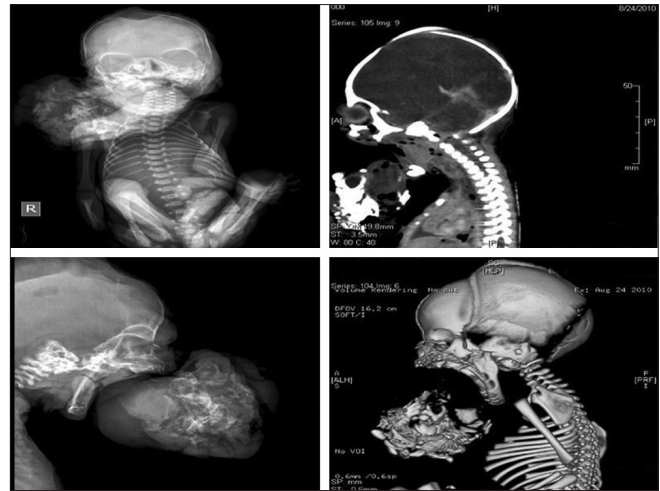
(a) Postmortem plain anteroposterior radiograph of the baby showing heterogeneously dense intraoral mass. (b) Lateral view of the mass. (c) Sagittal reformatted CT scan showing heterogeneous density mass arising from basisphenoid with no intracranial extension. (d) Sagittal view with 3D reconstruction
